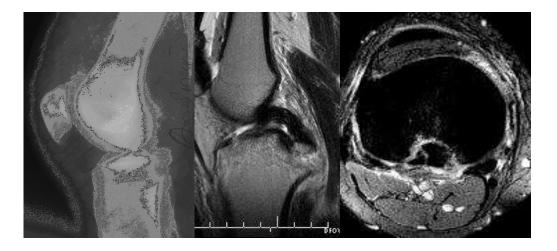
FIG40PLAIN RADIOGRAPH FIG41T2WSAG FIG43GRE
